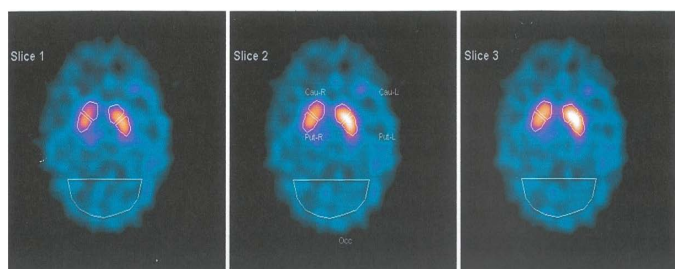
Clinical case 1: patient with MTHFR mutation type C677T and heterozygous Leyden V factor and cerebral vasculopathy. Brain [(123)I]-CIT SPECT examination (DatScan) 2019, January; first access to outpatient clinic, 2018, November.
